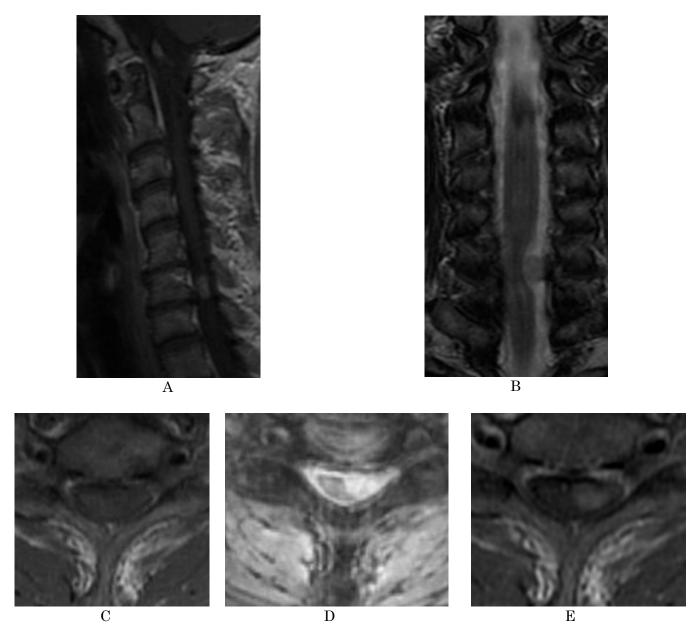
Preoperative magnetic resonance imaging of the cervical spine showing a 10 × 6-mm-sized intradural extramedullary mass on the left anterolateral side of the C6/7 level (A-E) (A) Sagittal T1-weighted and contrast-enhanced image. (B) Coronal T1-weighted and contrast-enhanced image. (C) Axial T1-weighted image. (D) Axial T2-weighted image. (E) Axial T1-weighted and contrast-enhanced image.
